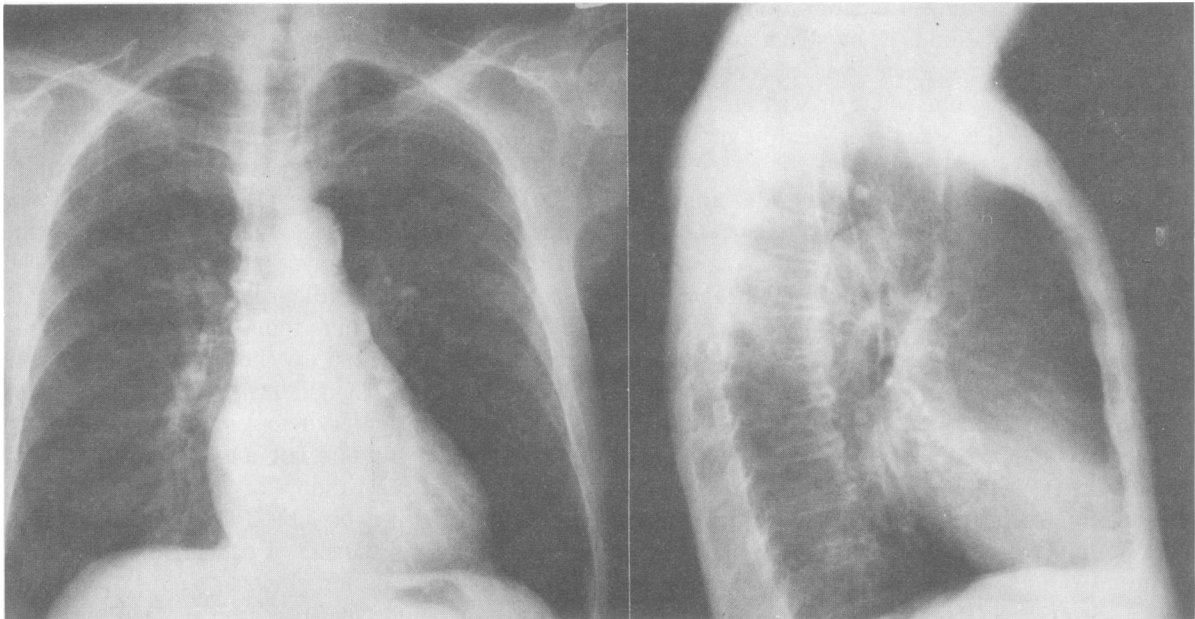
Posteroanterior and lateral x-ray studies of the chest in case 5. Calcification is present in the region of the left atrium.
